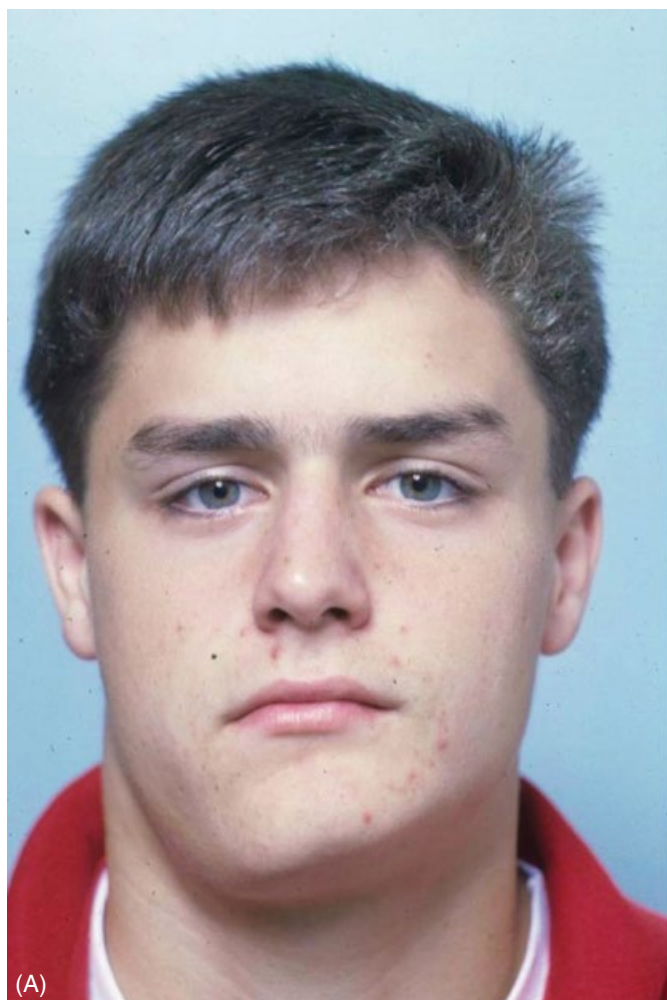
(A, B) Condylar hyperplasia and mandibular macrognathia, frontal view of patient and radiograph. Note grossly enlarged right condyle and enlarged inferior border of mandible producing severe facial asymmetry and malocclusion.
